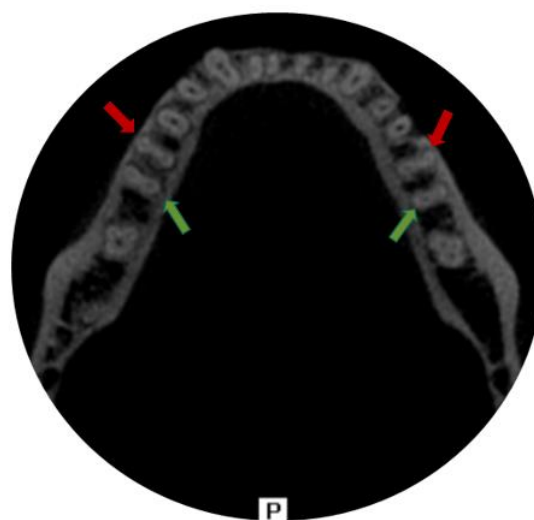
Axial CBCT image of the mandible showing bilateral mandibular molars with extra roots; RP in the mandibular first molars (red arrows) and RE in the mandibular first molars (green arrows).
